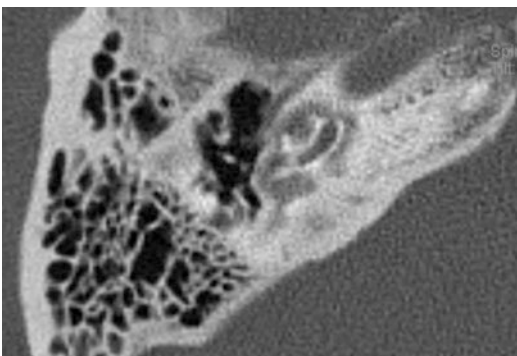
Axial temporal bone CT revealing pericochlear lucency consistent with extensive retrofenestral otosclerosis
